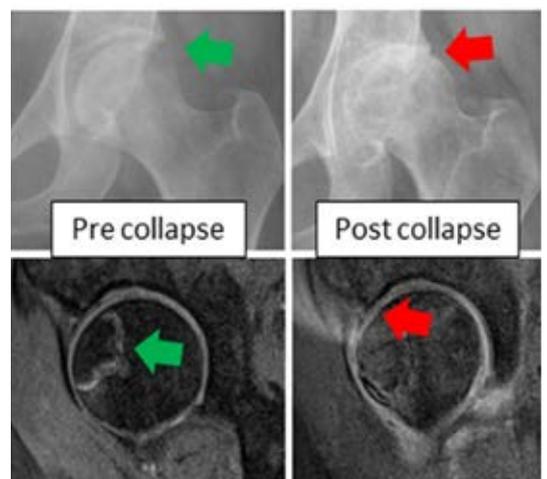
Typical changes seen on plain radiograph (top) and MRI (bottom) of the hip in early and late AVNFH. The appearance of early AVNFH is not apparent on plain radiograph but is visible on MRI
